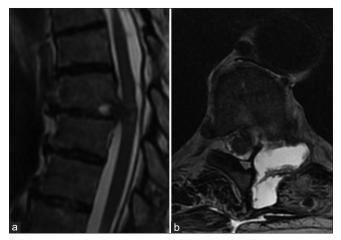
(a) Thoracic column magnetic resonance imaging (MRI), midline sagittal T2-weighted sequence and (b) thoracic column MRI, T8–T9 axial T2-weighted sequence. One-month postoperative MRI scan evidenced the presence of the median residual, a left paramedian liquor collection, and the removal of the recurrent thoracic disc herniation.
